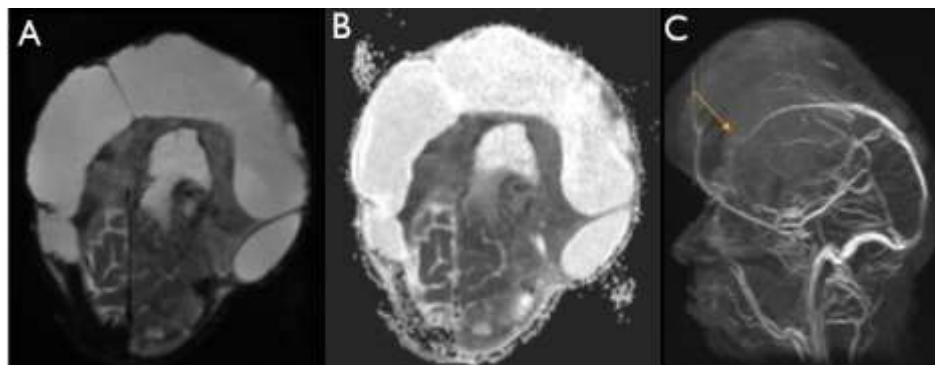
Functional and Vascular Imaging: (A) Diffusion-weighted imaging (DWI) and (B) ADC map showing restricted diffusion within the solid tumor components, suggestive of high cellular density. (C) Venous TOF-MRA (Lateral projection) showing the complete amputation of the anterior third of the superior sagittal sinus (white arrow)
